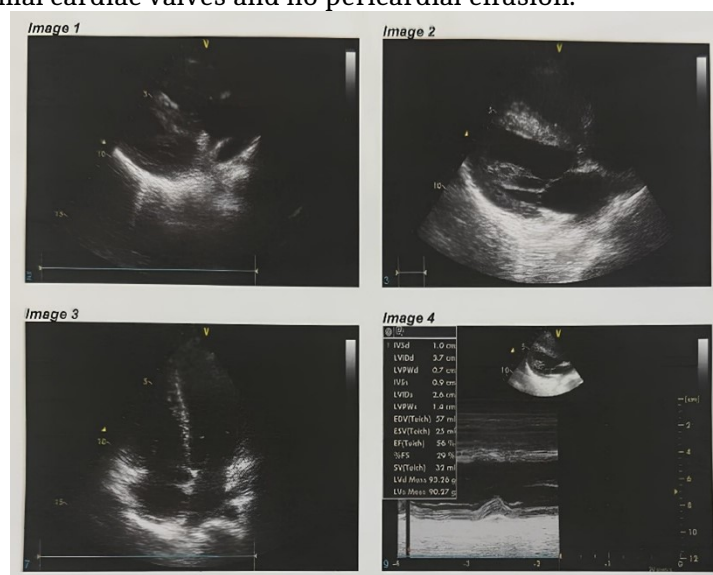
The echocardiogram showed a structurally normal heart (situs solitus, AV-VA concordance, all PV to LA, ASD (-), VSD (-), PDA (-), LVEF 56%, TAPSE 1.4 cm, with normal cardiac valves, mean pulmonary artery pressure of 5 mmHg, left-sided aortic arch, and no evidence of coarctation or pericardial effusion)
